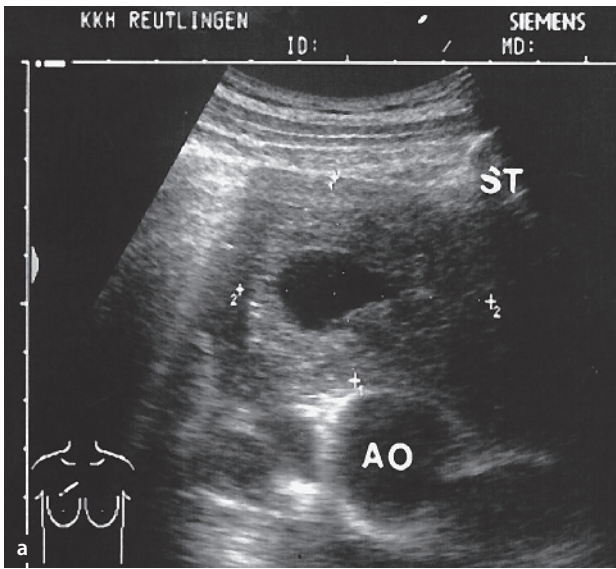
Thymoma. a Parasternal, transversal section. Even with the patient in the supine position, it was possible to see a low-echo mass in a ventral position to the aorta and well delineated. Central
